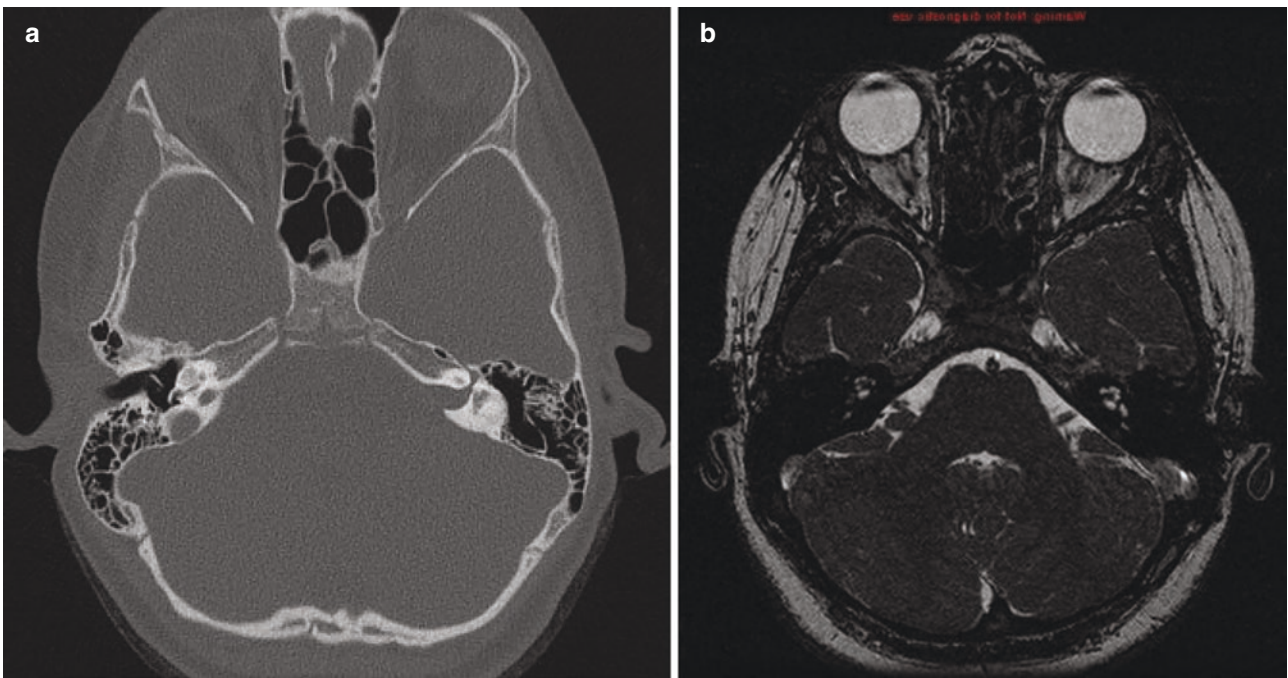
(a) A computed tomography scan of a patient with cochlear ossification as consequence of otitis media-associated labyrinthitis ossificans in the right ear. (b) T2WI MRI scan of the same patient, revealing a decreased T2 signal in the cochlea
